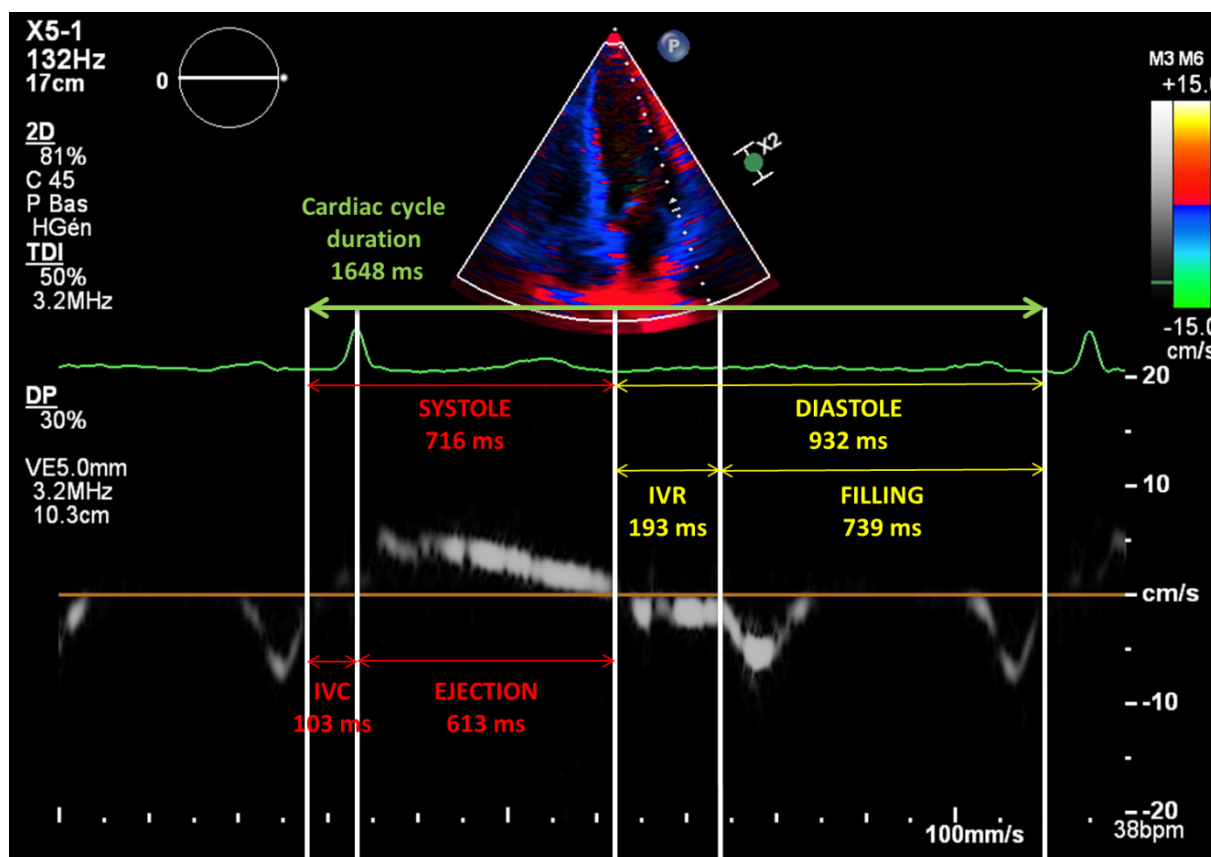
Tissue Doppler imaging at lateral mitral annulus, showing the different phases of the cardiac cycle in our hypothermic patient. IVC: isovolumic contraction time, IVR: isovolumic relaxation time.
